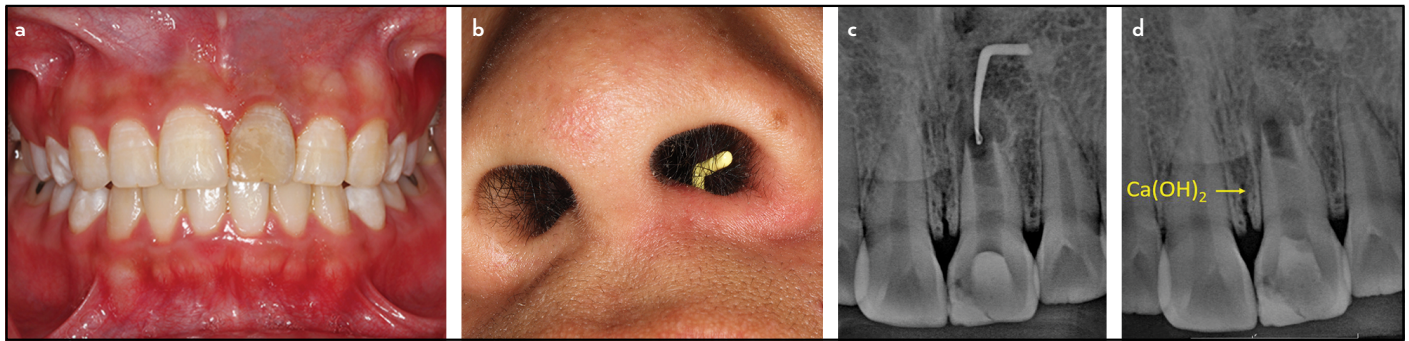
Extraoral photographs and initial radiographs. (a) Intraoral examination. (b) Sinus tract tracing from the nostril. (c) Radiograph of gutta-percha tracing. (d) Radiograph of calcium hydroxide hard packing medication
